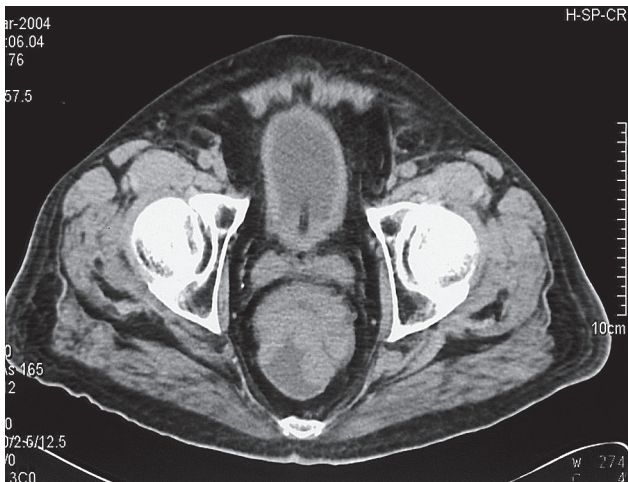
Abdominopelvic CT: villous tumor inside the digestive lumen; no adenopathies or signs of local invasion.
